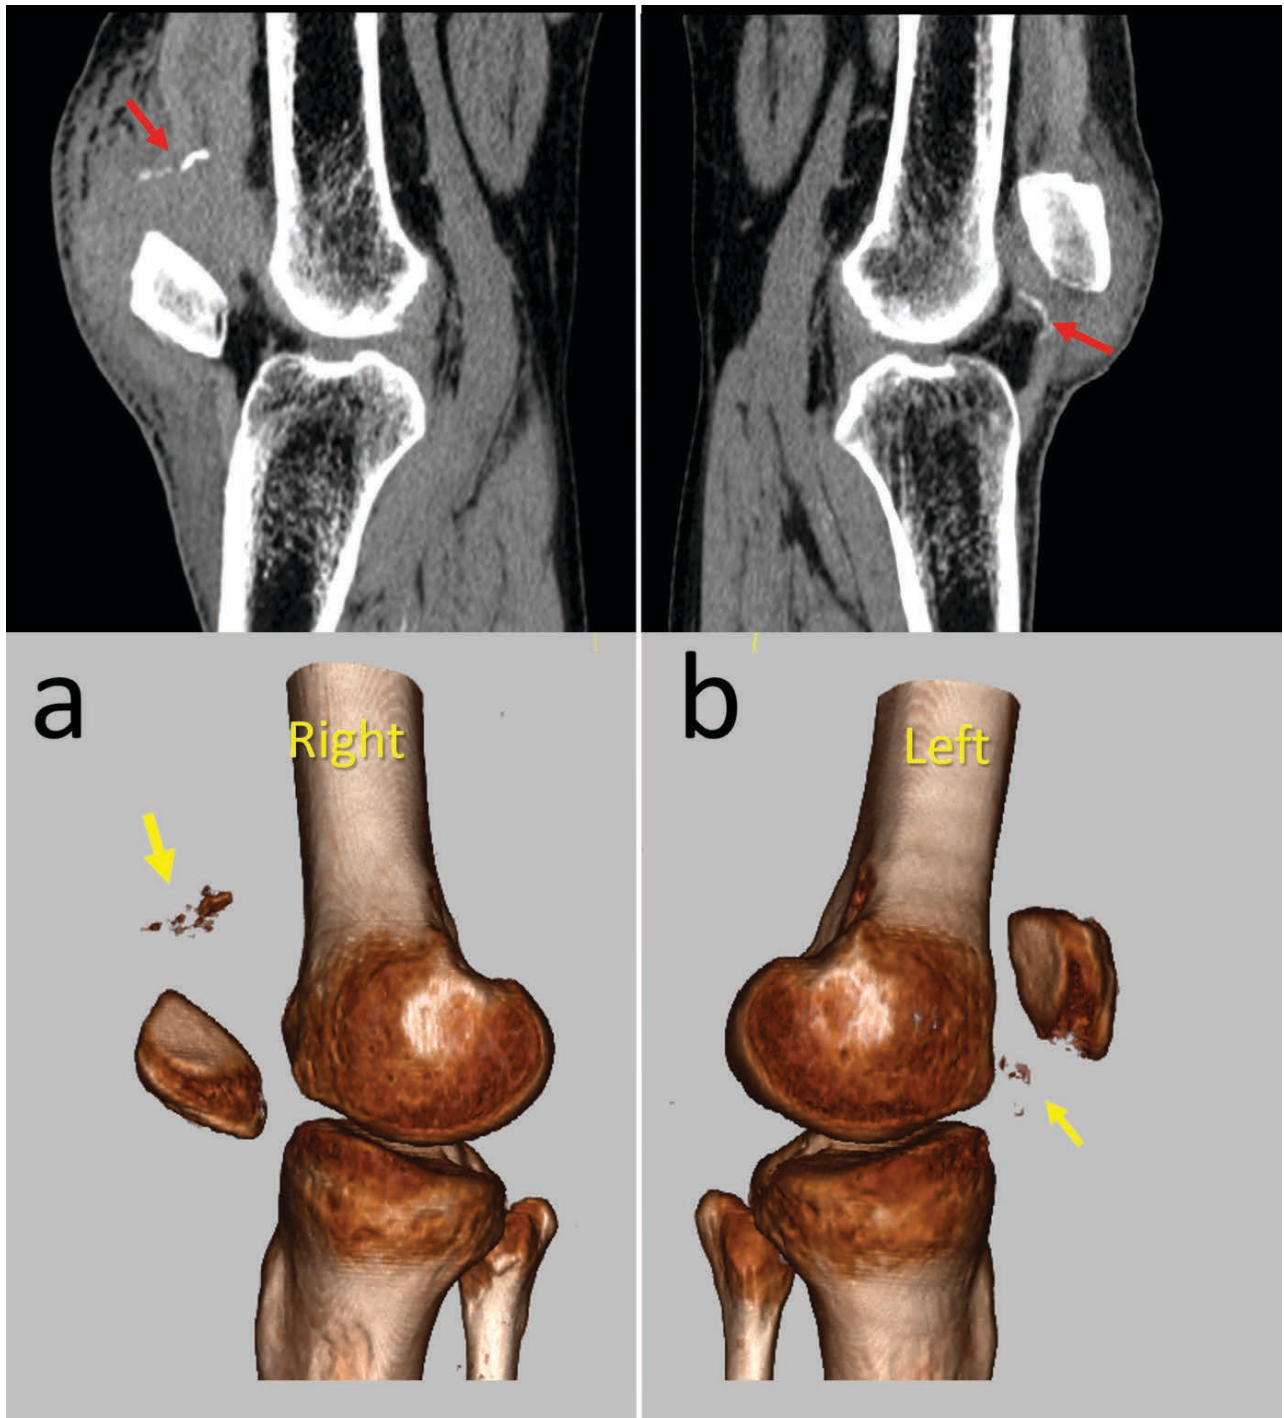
Sagittal and 3D CT images of both knees. The avulsion fractures from superior pole of right patella on right and inferior pole of left patella are clearly observed (arrows).
